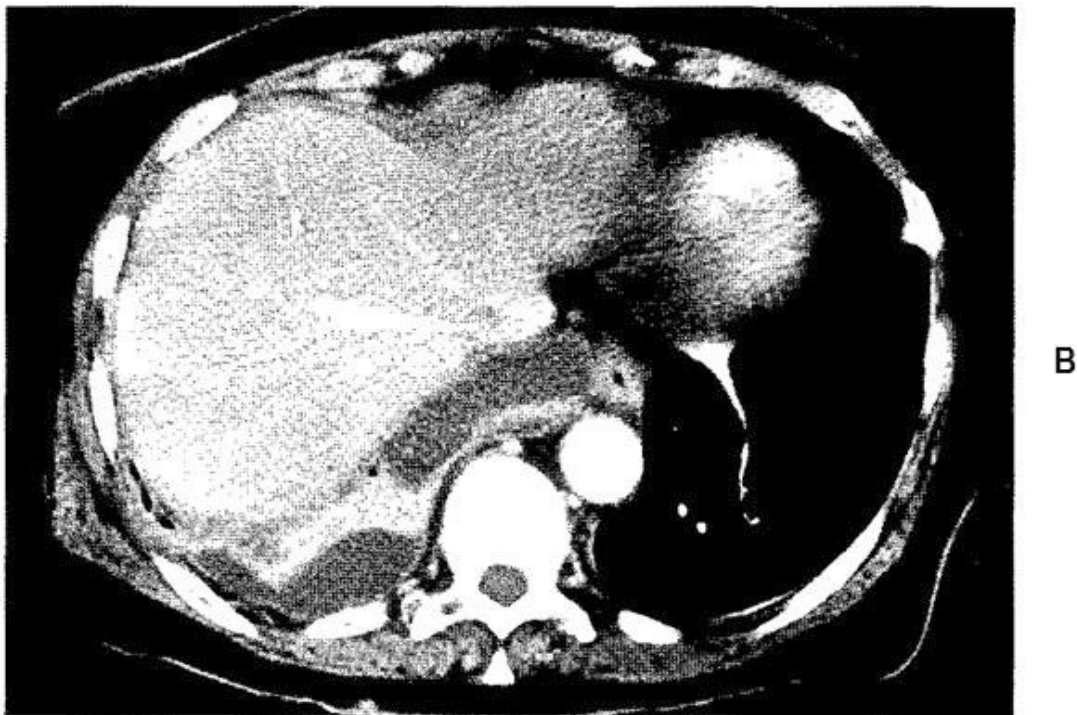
B, Patient A's CT scan revealed a subhepatic abscess that required surgical drainage.
